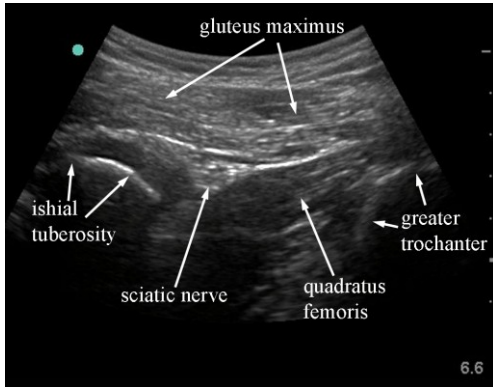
Sonogram of the sciatic nerve at the level of the ischial tuberosity in the buttock.
